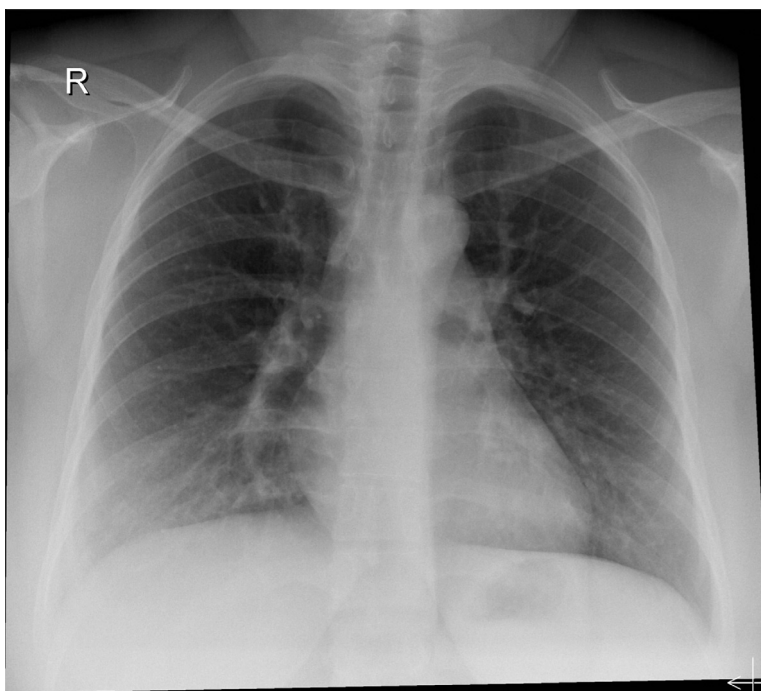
Chest X-ray frontal projection in the day of admission showing faint opacity within the right paracardiac region.
